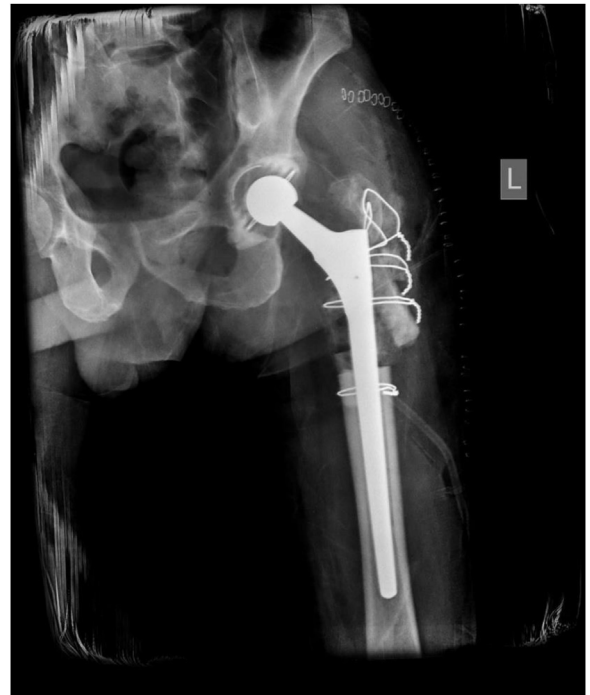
Immediate postoperative pelvis radiograph showing a satisfactory fit of the distally fitted uncemented femoral stem.
